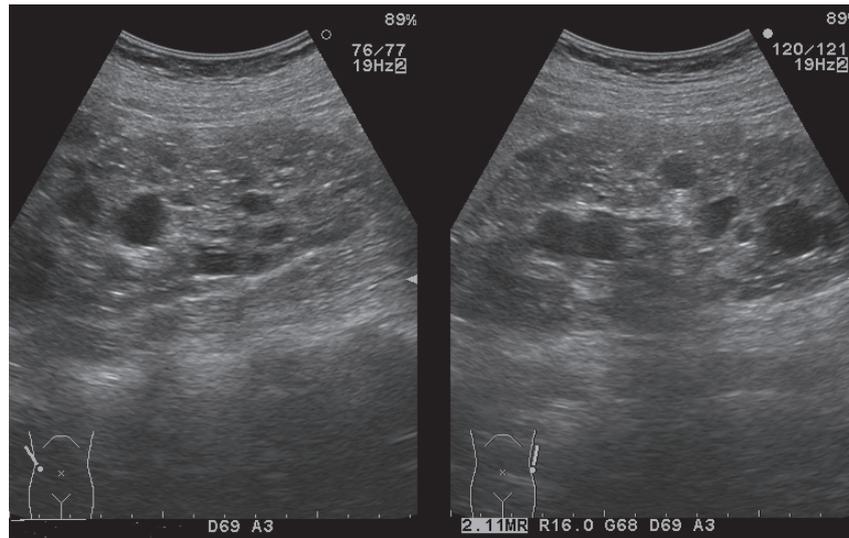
Representative Findings for Bilateral Multiple Renal Cysts on Abdominal Ultrasonography
